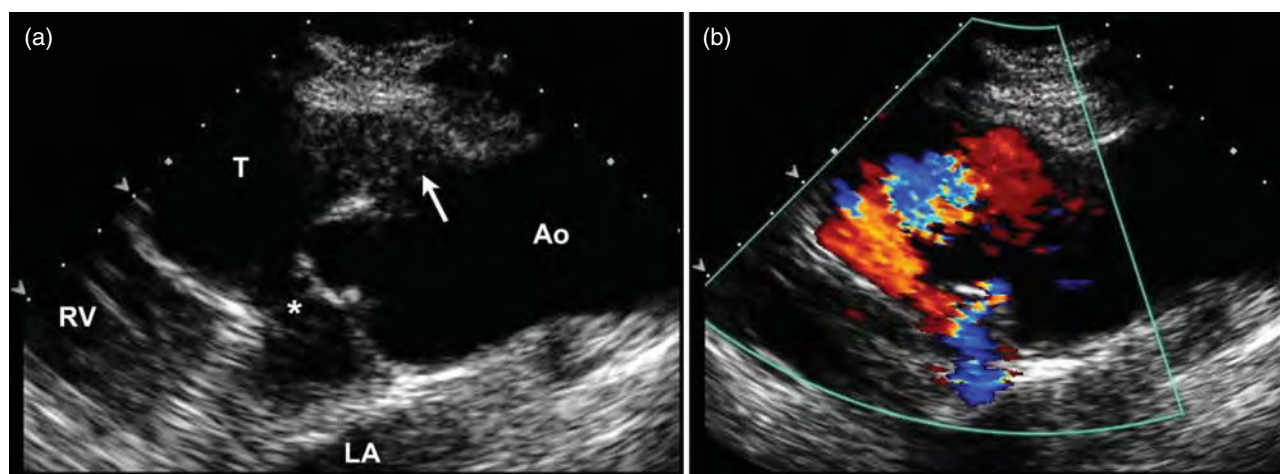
Echocardiographic long-axis images of a type 4 aorto-left ventricular tunnel. Both the aortic and ventricular orifice of this tunnel were large and the amount of diastolic flow was torrential (b). The arrow in (a) indicates the aortic orifice from the tubular ascending aorta, just above the sinotubular junction. The asterisk indicates the left ventricular exit orifice. Both the inlet and exit portions of this tunnel were severely dilated (T). The aortic valve had mild central regurgitation, but no stenosis. RV, right ventricle.
